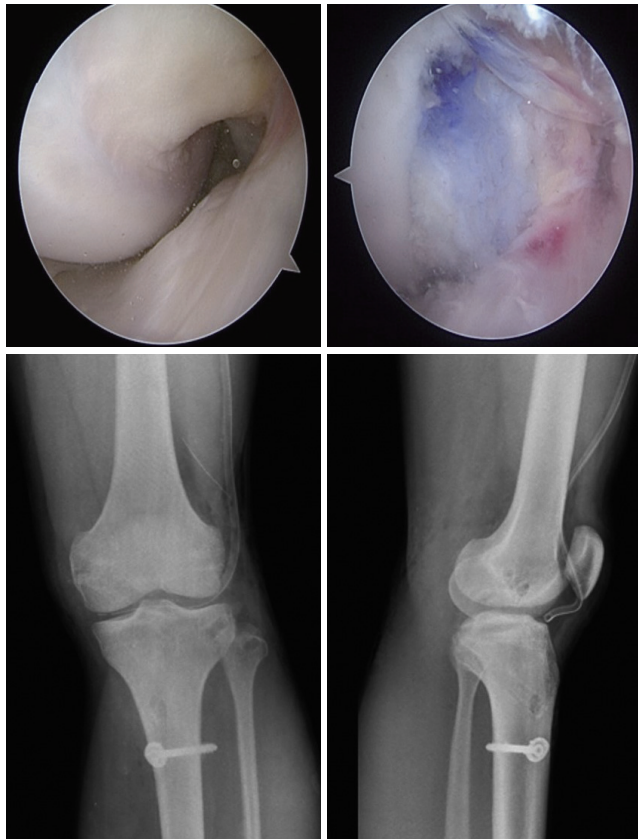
Arthroscopic findings and postoperative radiographs. Arthroscopic findings show chronic rupture of the PCL and anatomical reconstruction. Radiographs show the femoral and tibiofibular tunnel positions of the PCL and posterolateral complex reconstruction. PLC, posterolateral complex; PCL, posterior cruciate ligament.
